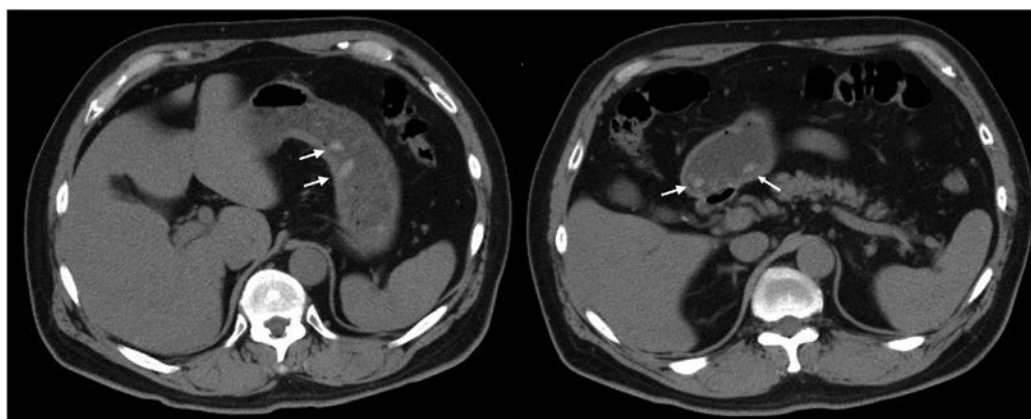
Abdominal computed tomography demonstrating multiple stick-like and rod-shaped high-density structures in the stomach, which presumably represented heat-not-burn cigarette fragments (arrow). Mean Hounsfield units of the 4 structures marked were 65.5
